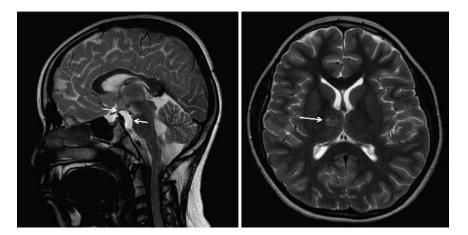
(Left) Sagittal T2-weighted images of the patient's brain reveal a prepontine cystic mass with wall enhancement and ventral mural nodule (arrows). (Right) Axial T2-weighted magnetic resonance image reveals a patchy signal abnormality of the right thalamus (arrow).
